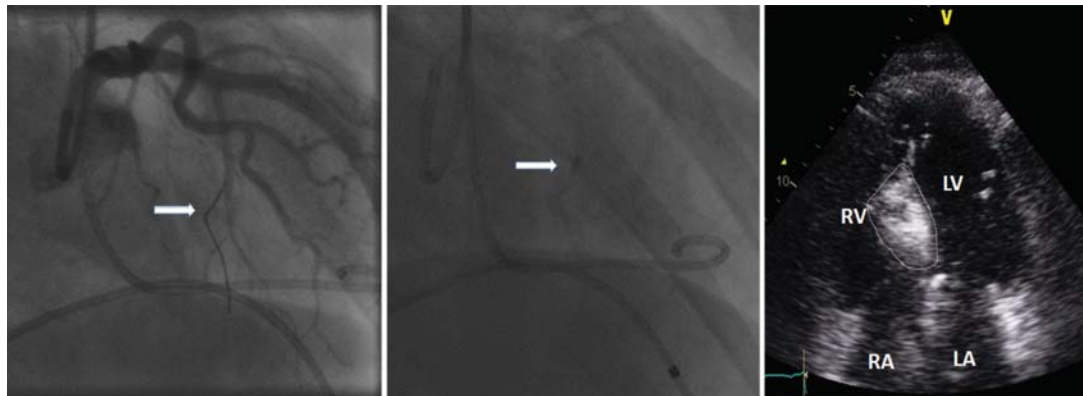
Once again change of interventional strategy in the patient of (Figs. 1-3) after documented misplacement twice in myocardial contrast echocardiography (Figs. 2 and 3). The proximal proximally pointing final branch of the dominant septal branch (number 3 in Fig. 1) is inserted with the guidewire (left, arrow) and selective septal angiography is performed (middle, arrow) after myocardial contrast echocardiography (right) has depicted precise opacification of the target septal area without any misplacements. LV: left ventricle, RV: right ventricle, LA: left atrium, RA: right atrium.
